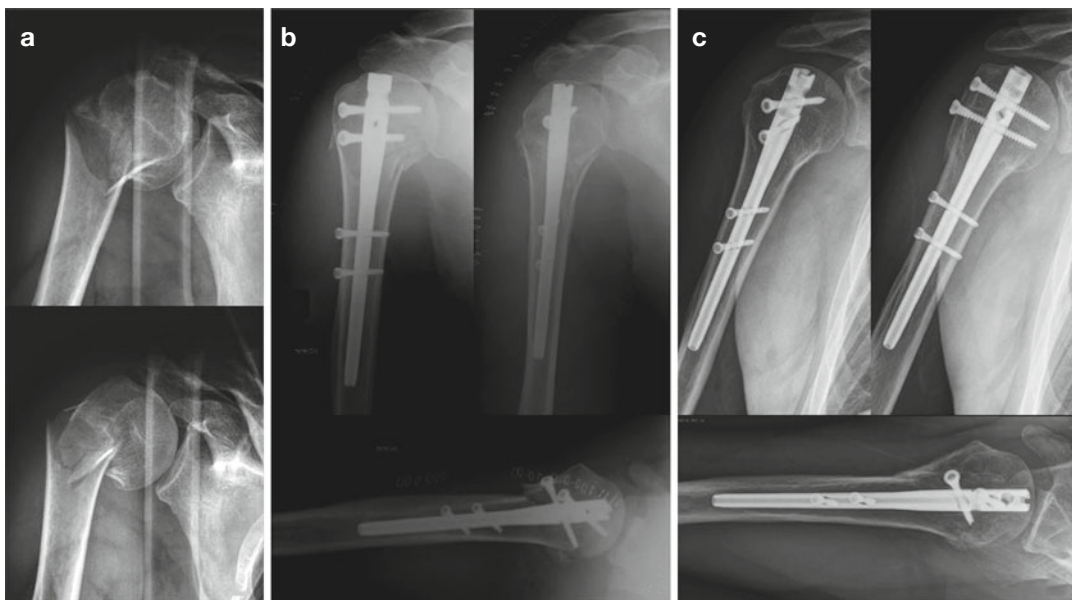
Surgical neck fracture in a 57-year-old man. (a) Preoperative radiographs showing metaphyseal comminution. (b) Reduction and fixation with an angular
